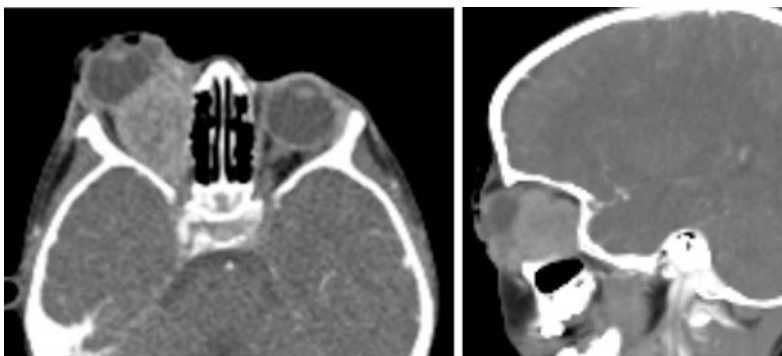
A 4 years old boy with rhabdomyosarcoma of the right orbit. a–b Axial and sagittal post contrast CT images reveal right intra-orbital homogenous enhancing lesion with associated marked proptosis of the right eye globe
